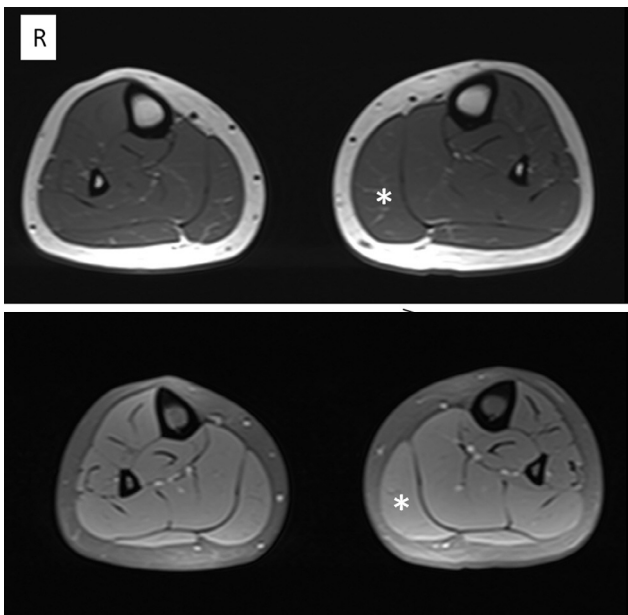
Lower leg MRI: Axial T1 weighted image shows enlarged left-sided medial head of the gastrocnemius muscle (asterisk).
